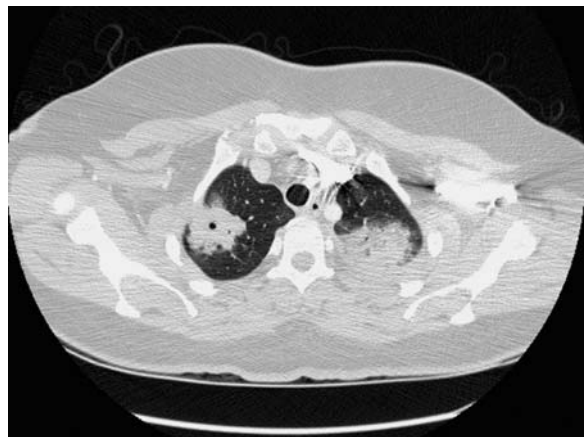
Polymicrobial bacterial pneumonia in a 33-year-old woman. Chest CT scan (collimation 16×1.25 mm) shows bilateral nodules in upper lobes. Note small area of necrosis in right upper lobe lesion
